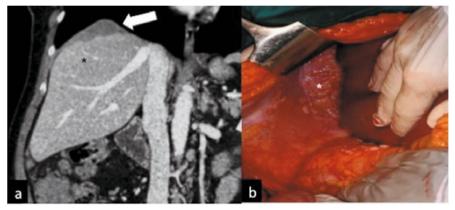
Coronal computed tomography (CT) image showing (a) irregular soft tissue (*arrow*) of inconstant extension formed by the confluence of multiple nodular implants in the right subdiaphragmatic space scalloping the liver surface and presenting a lower density than the parenchyma (*black asterisk*) on contrast-enhanced scan. b During surgical intervention, the pathological subdiaphragmatic tissue was confirmed (*white asterisk*)
